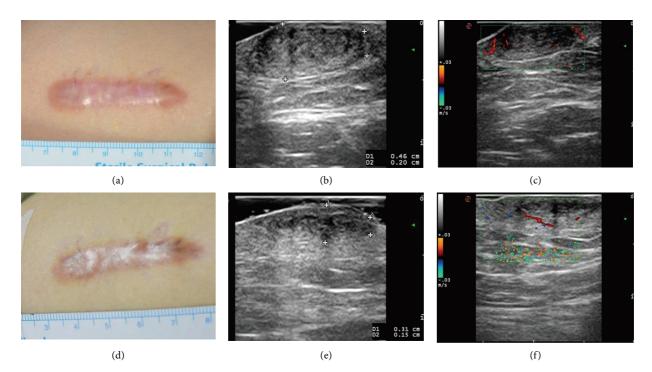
Representative case in Group 2. A 34-year-old female had post-operation hypertrophic scar in shoulder for 8 months. (a, d) Following the 6 sessions of medium-dose 5-FU and TAC treatment, the hypertrophic scar was markedly flatter. (b, e) The ultrasound imaging showed the thickness of hypertrophic scar was reduced. (c, f) The ultrasound imaging showed the vascularity reduction following the injection treatment.
